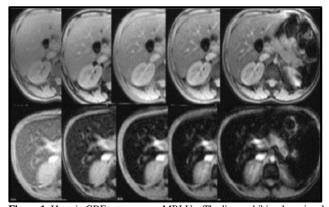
Hepatic GRE sequence on MRI Up: The liver exhibits slow signal loss in the images from the five initial echoes. The R.2" is 47Hz, suggesting the lack of iron overload and a LIC of 1.39 mg Fe/g dry liver. Down: The liver's signal is rapidly deteriorating. The R.2 is 700 Hz, indicating a significant iron overload of 18 mg Fe/g dry liver^[8]
